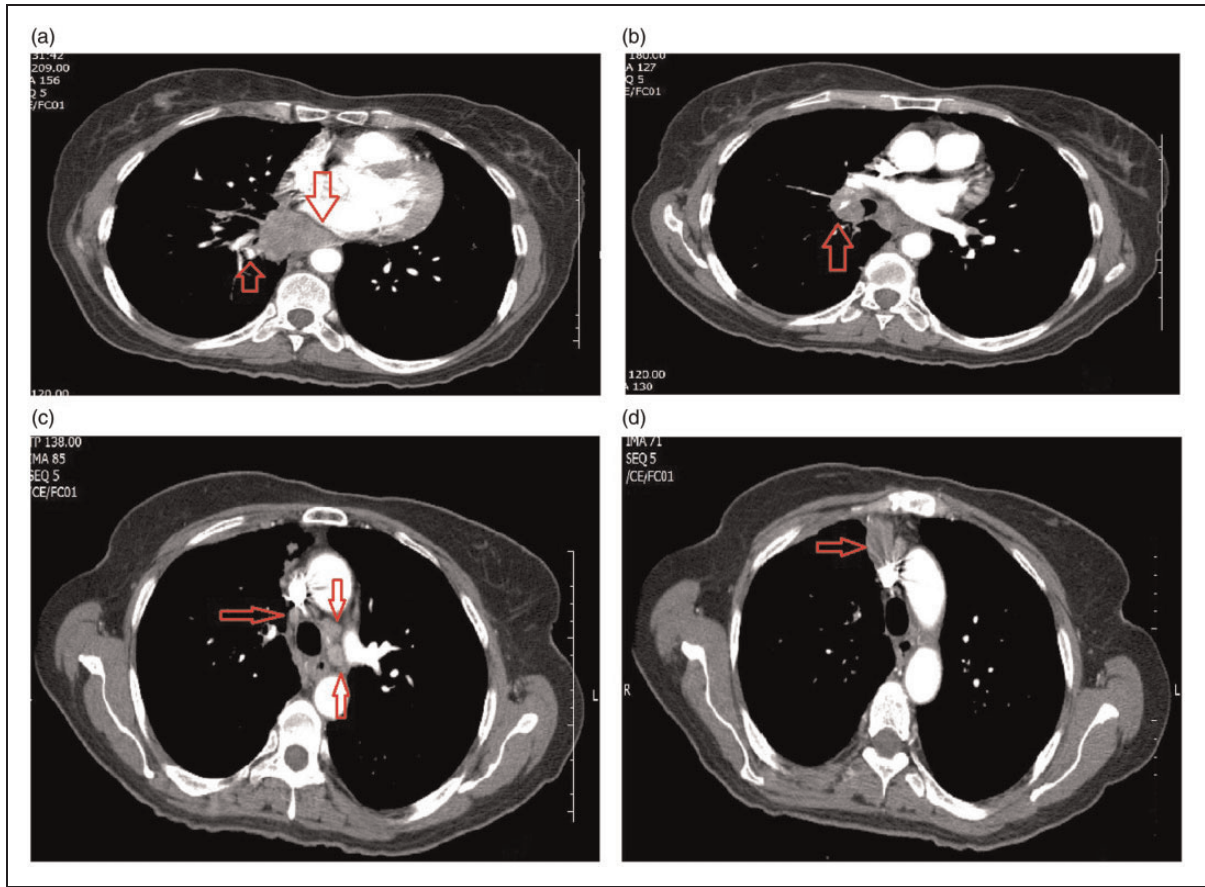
In the axial sections of the thorax computed tomography taken at the time of diagnosis: a malignant mass lesion extending to the subcarinal, paraaortic area is observed in the right hilar region (a), there are large lymph nodes in the right hilar, aortopulmonary, paratracheal, anterior mediastinal areas (b, c, d).
